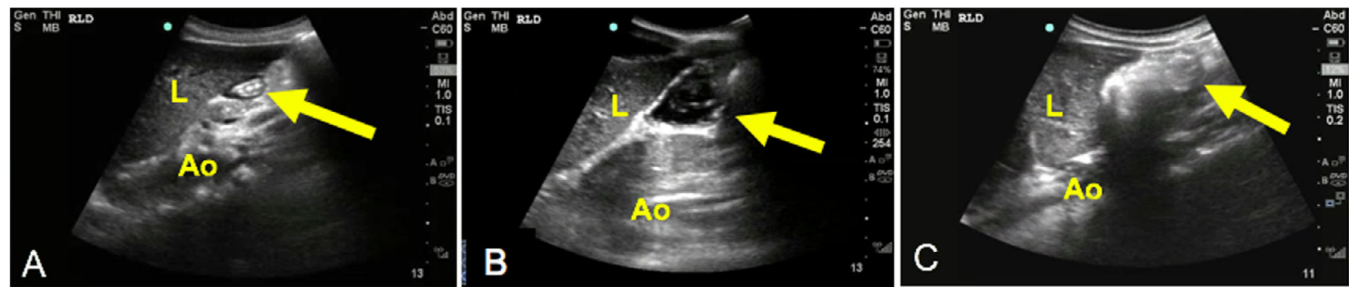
Gastric content as visualized by POCUS. Ultrasound images of the gastric antrum in the epigastric area obtained in a sagittal plane in the RLD position, representing (A) empty, (B) liquid, and (C) solid contents. An empty antrum appears flattened and devoid of contents. Liquid contents appear hypoechoic or anechoic, and solid contents appear hyperechoic, often with particulate content. Yellow arrow = antrum. Ao = aorta; L = liver; POCUS = point-of-care ultrasound; RLD = right lateral decubitus.
